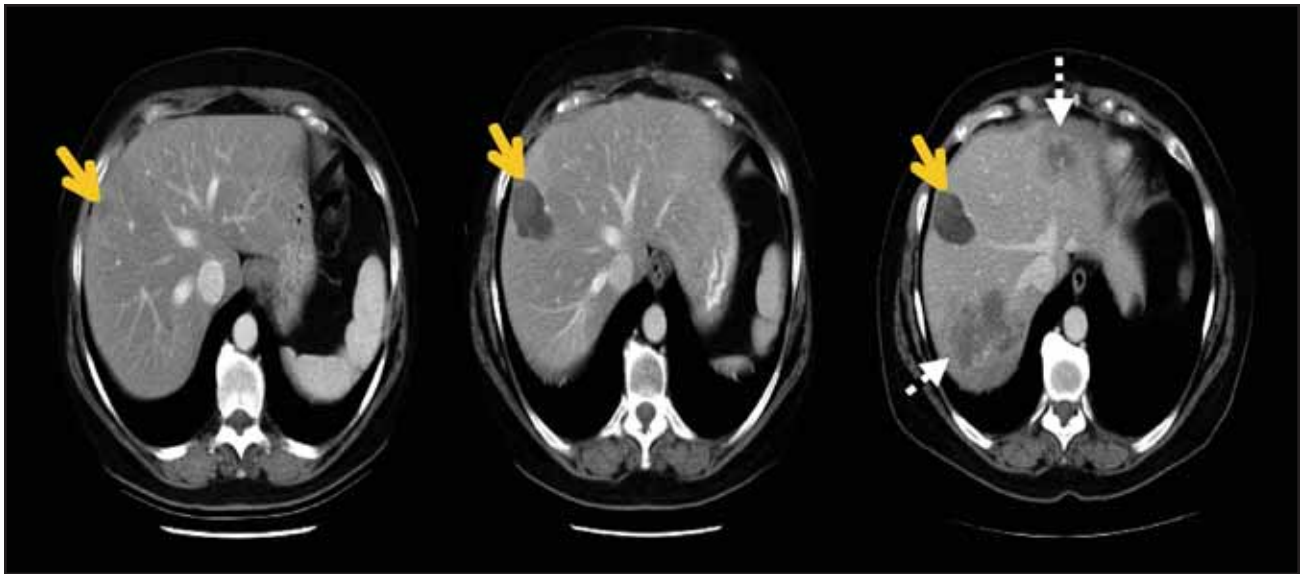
Computed tomography appearance of a hepatic metastasis from CRC treated by RFA. The original lesion (arrow at left) was treated by RFA shortly after this exam was performed. Six months later, the ablation defect is characteristically larger and hypovascular. At 1 year after RFA, the defect has not increased in size or appearance, affirming destruction of the metastasis. However, new hepatic metastases (broken arrows) have developed in distant areas of the liver and appear distinctly different.
